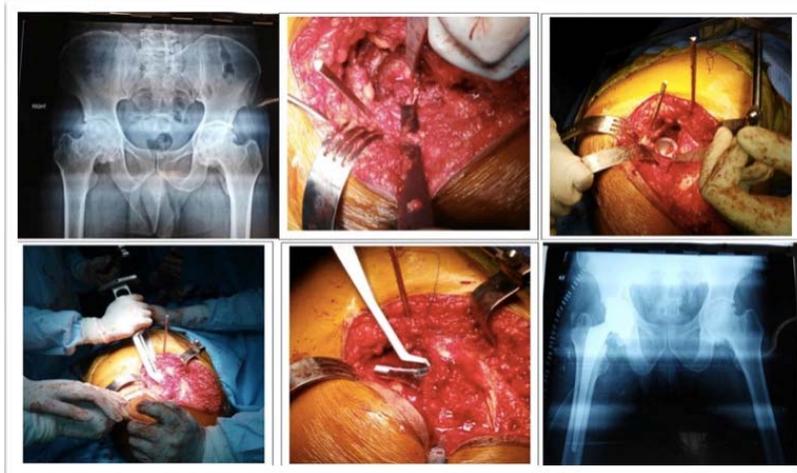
Image showing (Clockwise from Left Upper corner) preoperative X-Ray, Surgical procedure consisting of exposure of acetabulum, Acetabular component positioned in situ, Femoral preparation, Femoral component positioned in situ and immediate post-operative X-Ray
